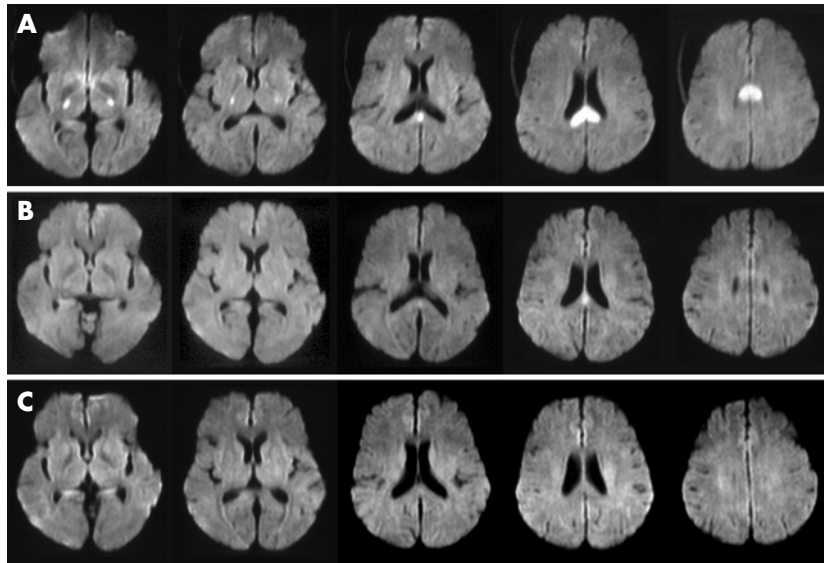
(A) Diffusion-weighted imaging (DWI) on admission showing hyperintense lesions in the splenium of the corpus callosum and the bilateral posterior limbs of the internal capsules. (B) DWI obtained 2 h after glucose infusion showing almost full recovery except for a small part of the splenium of the corpus callosum. (C) DWI obtained 2 days after glucose infusion showing complete regression of the hyperintense lesions.
